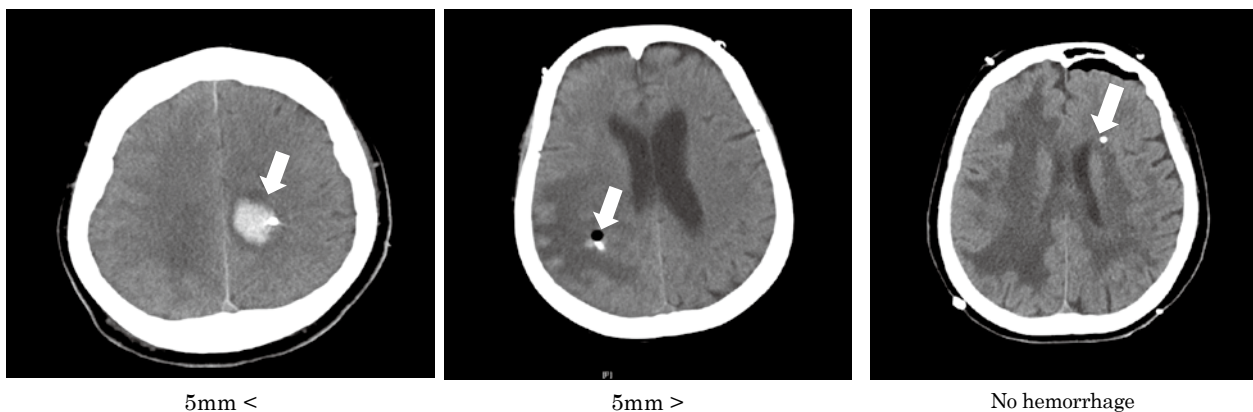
Representative images of stereotactic biopsy-related hemorrhages. Representative computed tomography (CT) images of hemorrhages > 5 mm in size (left panel), hemorrhages < 5 mm (middle panel), and no hemorrhages (right panel).
